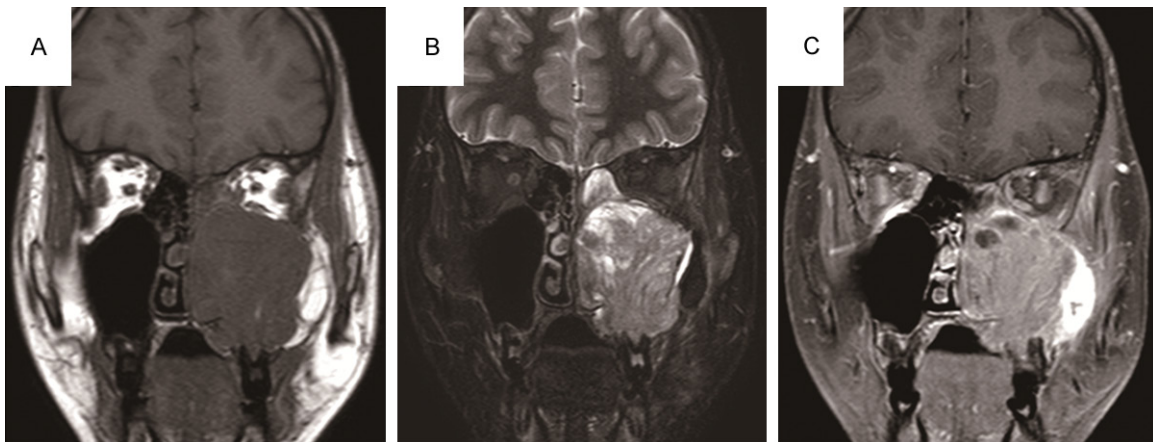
Magnetic resonance imaging. A. T1 weighted image revealing a mass with low intensity. B. Fat-suppressed T2 weighted image, exhibiting a mass with heterogeneously moderate to high intensity. C. Contrast-enhanced fat-suppressed T1 weighted image revealing a mass with moderate enhancement.
